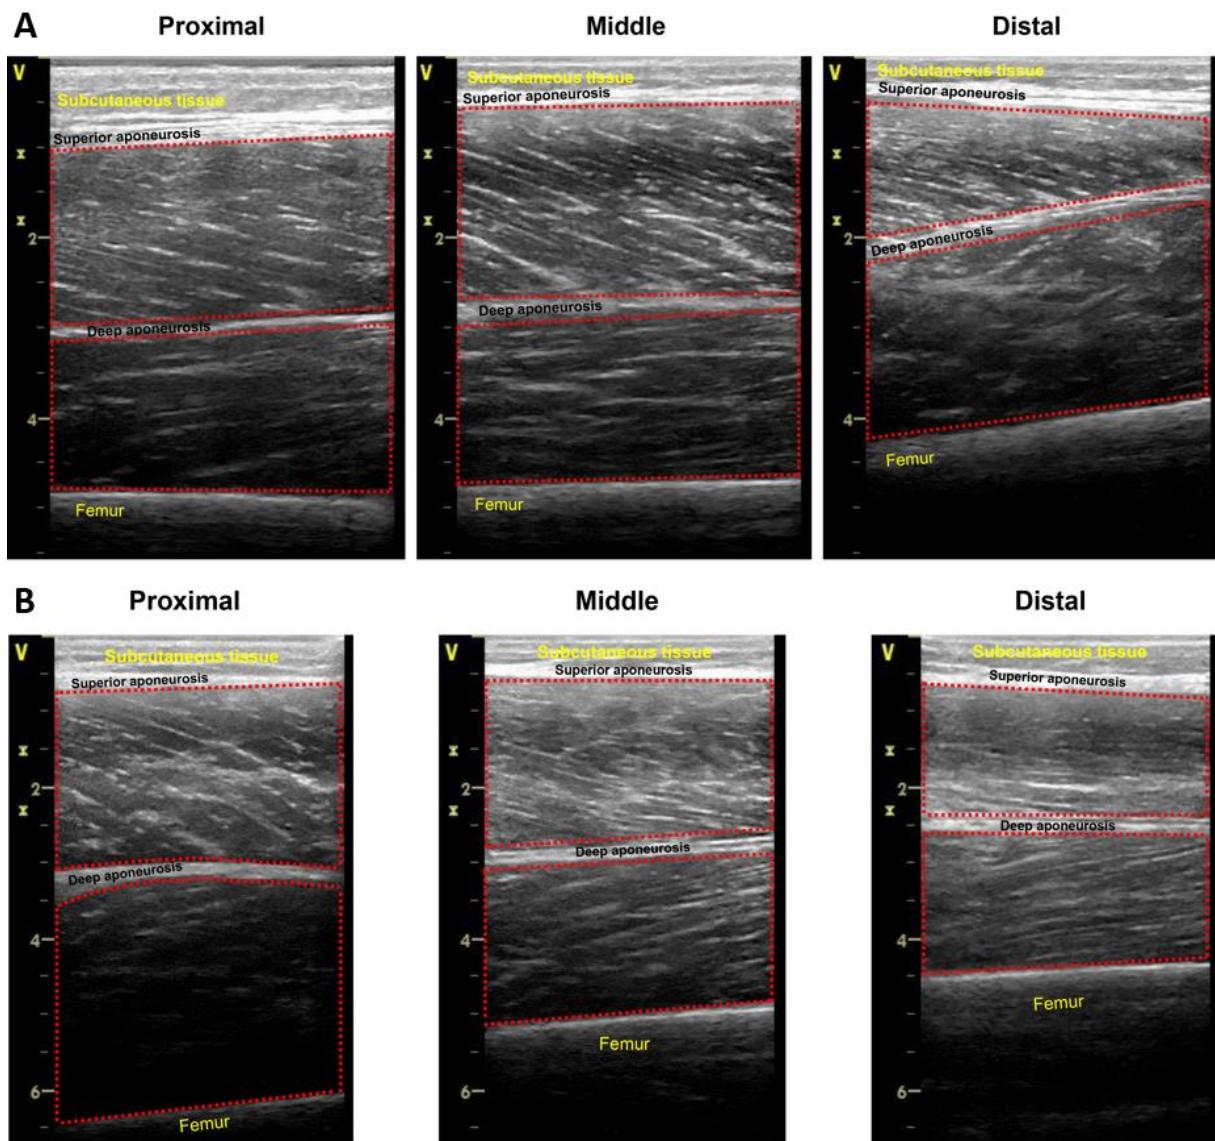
Representative B-mode ultrasound image of the proximal, middle, and distal vastus lateralis (top muscle) and lateral vastus intermedius (bottom muscle) (A). Representative B-mode ultrasound image of the proximal, middle, and distal rectus femoris (top muscle) and anterior vastus intermedius (bottom muscle) (B). The area inside of the dotted line represents the region of interest for each region and muscle.
